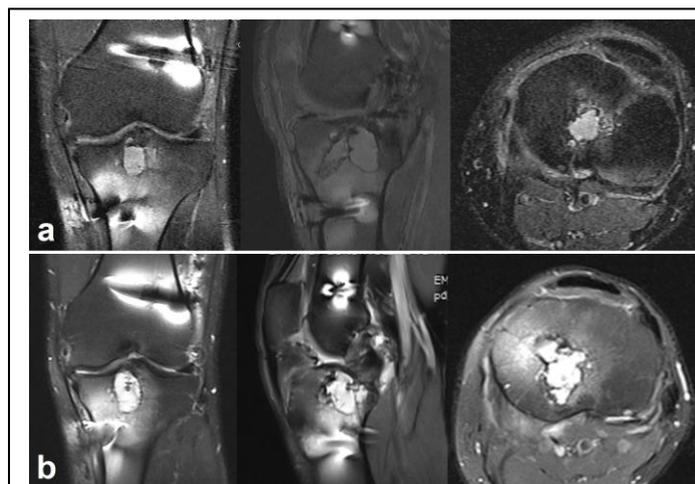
MRI sequences of the tibial cyst at 7 (a) and 9 (b) years after the initial surgery.
